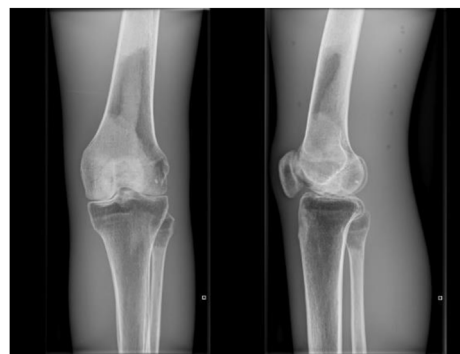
Images produced using the pre-set exposure for AP and Lateral knee X-rays.
